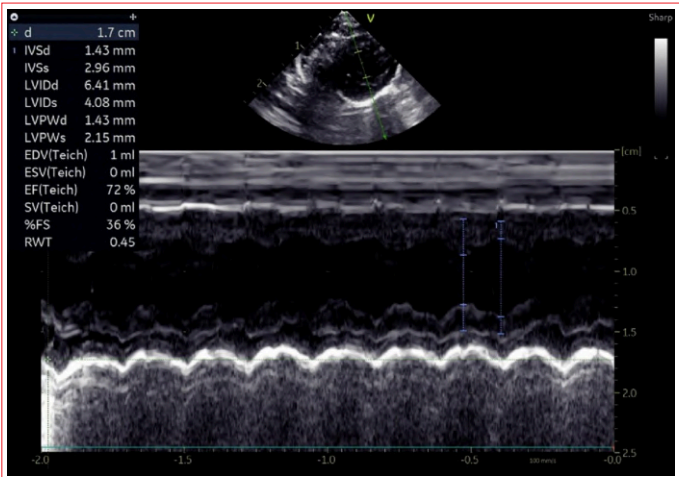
Methods 4. Calculation of left ventricular ejection fraction using the teicholz method via M-Mode echocardiographic evaluation from the parasternal short-axis view.
